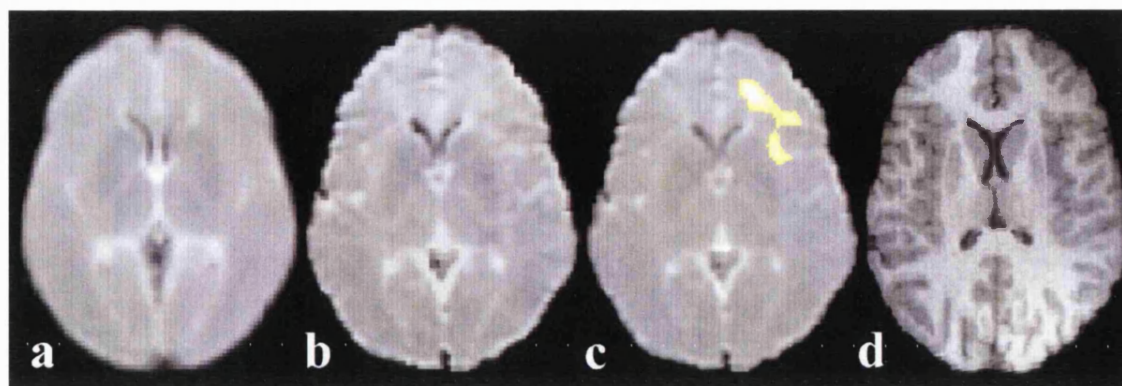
Patient 49, right frontal lobe epilepsy with normal conventional MRI.
